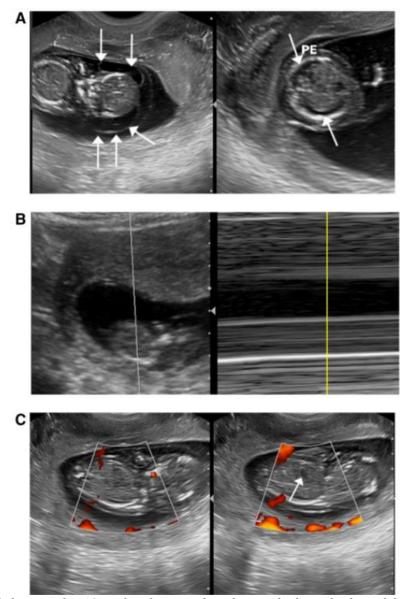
Transabdominal ultrasound at 13 weeks of amenorrhea showing hydrops fetalis and demise in a pregnant woman who was positive for SARS-CoV-2 at 8 weeks of gestation. (A) Extensive subcutaneous edema (white arrows) and pleural effusion (PE). (B) Images showing absent cardiac activity. (C) Absence of blood flow in the fetal heart (arrow).
